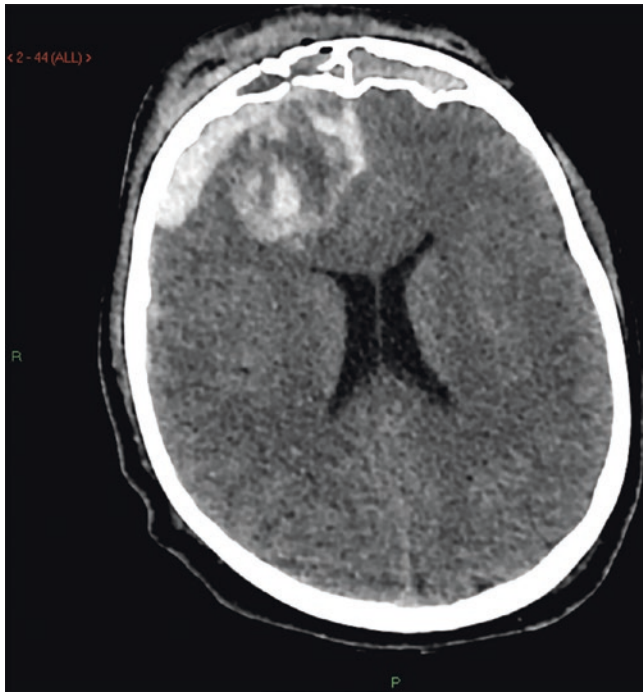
Large frontal cerebral contusion. Axial CT image shows a large parenchymal haemorrhage in the right frontal lobe, adjacent to a compound fracture of the right frontal sinus. There is blood within the frontal sinuses and a right frontal subdural haematoma
